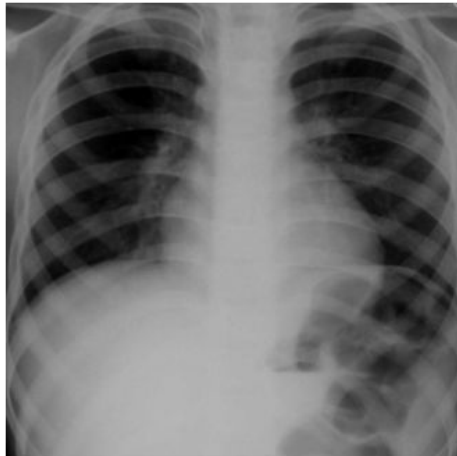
An x-ray of the thorax acquired from Rigshospitalet.
